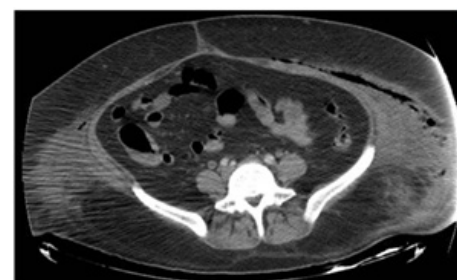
CT scan prior to second intervention that shows subcutaneous emphysema and what it seems and abscess formation.
